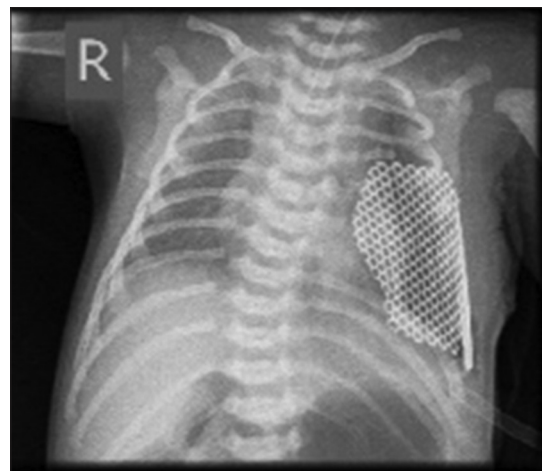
In the postoperative chest X-ray, reconstitution of chest wall with titanium mesh is notable
